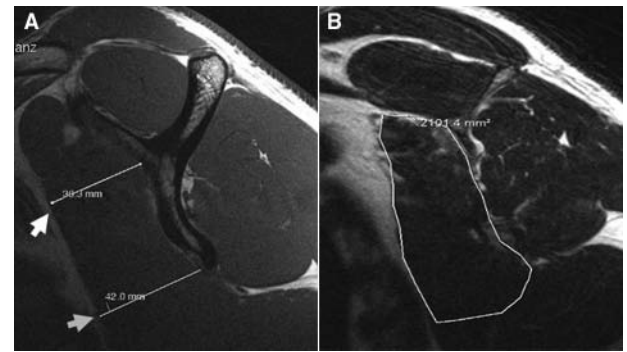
Subscapularis MRI parameters in the sagittal plane. A, Cranial-transversal diameter (white arrow) and caudal-transversal diameter (gray arrow) of the subscapularis muscle measured in millimeters. B, Subscapularis muscle cross-sectional area on the Y-shaped view measured in square millimeters.
